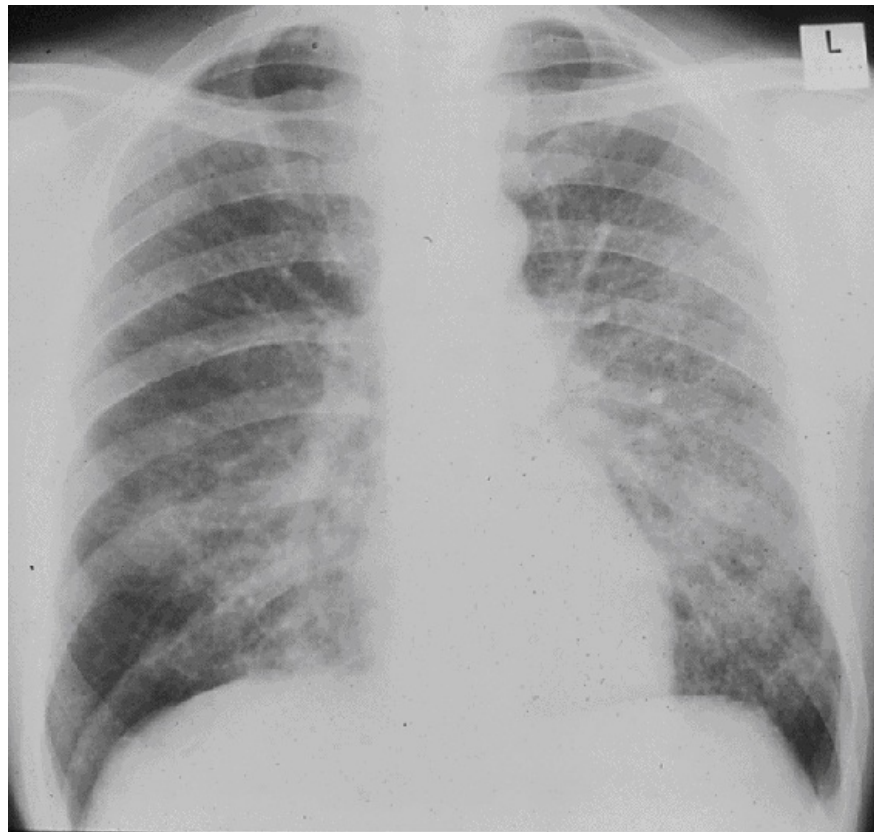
Bilateral Interstitial Infiltrates on Chest X-ray
